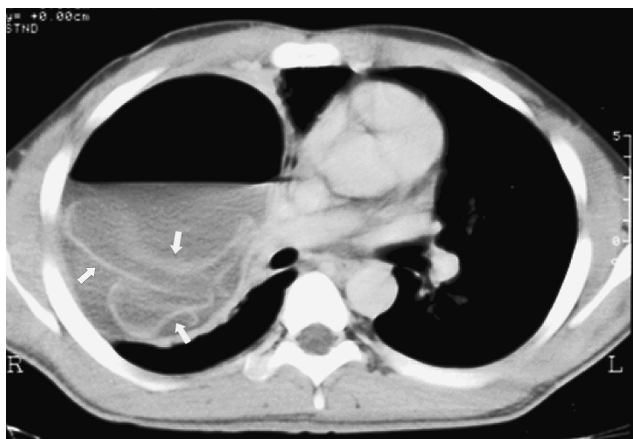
Chest radiograph showing a ruptured hydatid cyst with a free-floating membrane inside the cystic cavity as water lily sign
